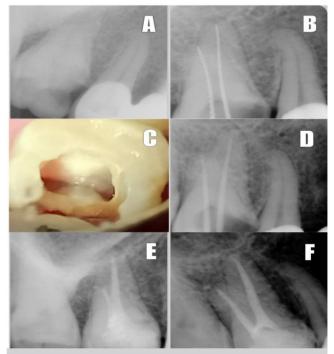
(A) Preliminary radiograph of the right upper 1st molar with one root on the buccal aspect (A); Working length determination (B); Two openings identified in the bottom of the pulp chamber (C); Master cone confirmation (D); Post obturation radiograph with cone shift (E & F).
